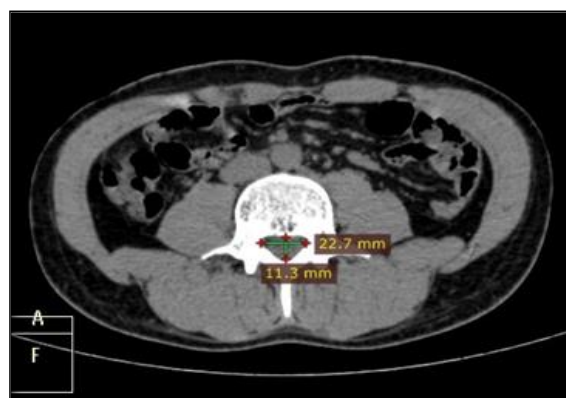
Measurement of the spinal canal in CT of living subjects
